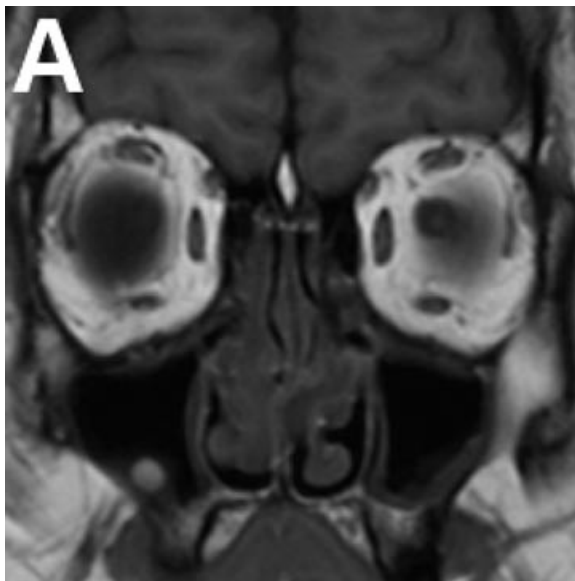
The fungal lesion in the right maxillary sinus: of a high signal intensity in the T1-weighted image – A, low signal intensity in the T2-weighted image – B, not distinguishable from mucosal thickening in CT – C.
